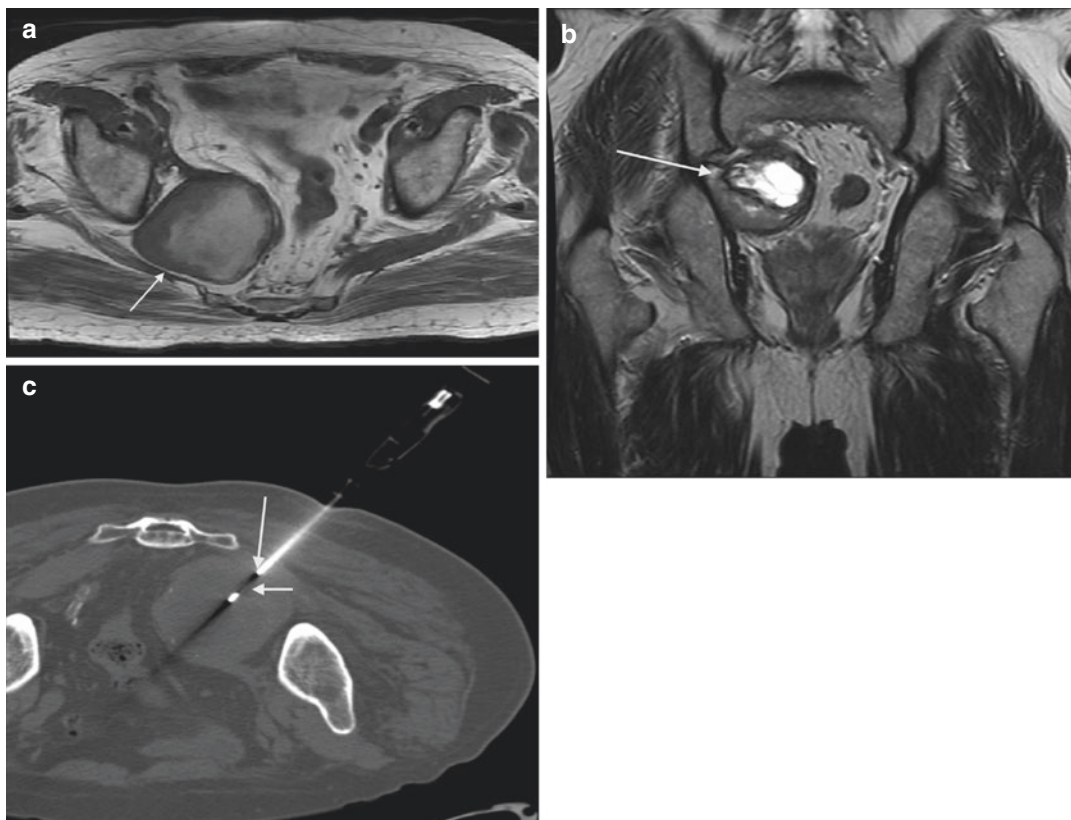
A 77-year-old male with right leg pain. T1-weighted axial image (a) shows a large mass (arrow) anterior and lateral to the lower sacrum and anterior to the piriformis muscle. T2-weighted coronal image (b) shows
